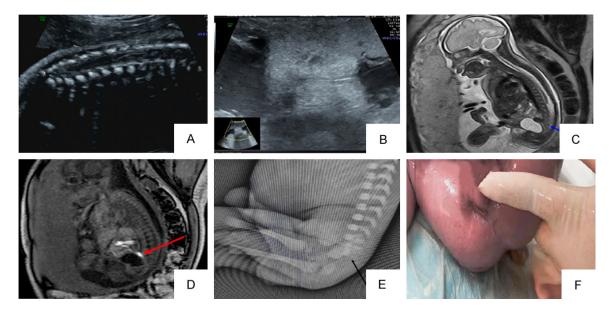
CRS, 25 weeks pregnant. A. Sagittal 2D ultrasound view of the fetal lower spine showing a defect in the lumbosacral vertebral body. B. 2D ultrasound showing only a linear hyperechoic structure with no target sign in the fetal anus. C. Sagittal prenatal MRI view SSFSE-T2W1 of the fetal lower spine showing a defect in the lumbosacral vertebral body. D. Sagittal SSFSE-T1W1 showing the proximal end of the rectum. Its distal end is not shown. E. Lateral X-ray of the spine after labor induction showing a defect in the lumbosacral vertebral body. F. After labor induction, no anal recess or anal atresia were found. Abbreviations: CRS, caudal regression syndrome; 2D, two-dimensional; MRI, magnetic resonance imaging.
